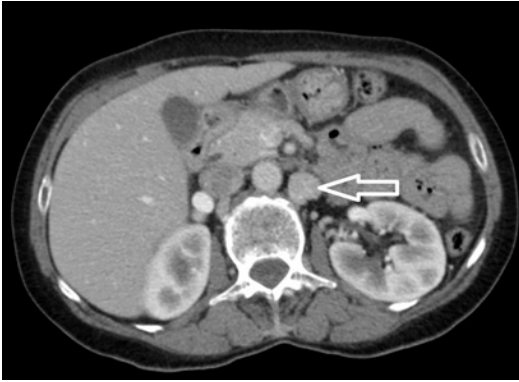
Axial CT image demonstrating a small left para-aortic "mass" (arrow).
